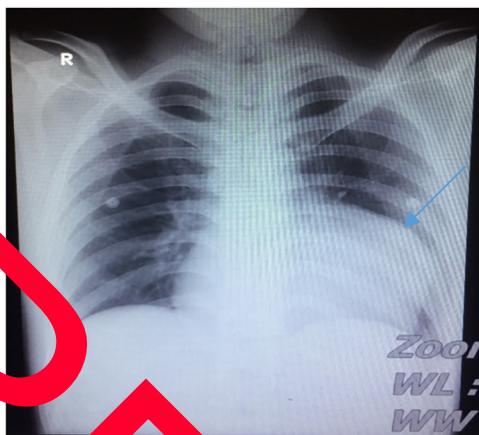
Posteroanterior Chest Radiography. A slightly prominent apex of left heart border (Blue Arrow) is seen.
